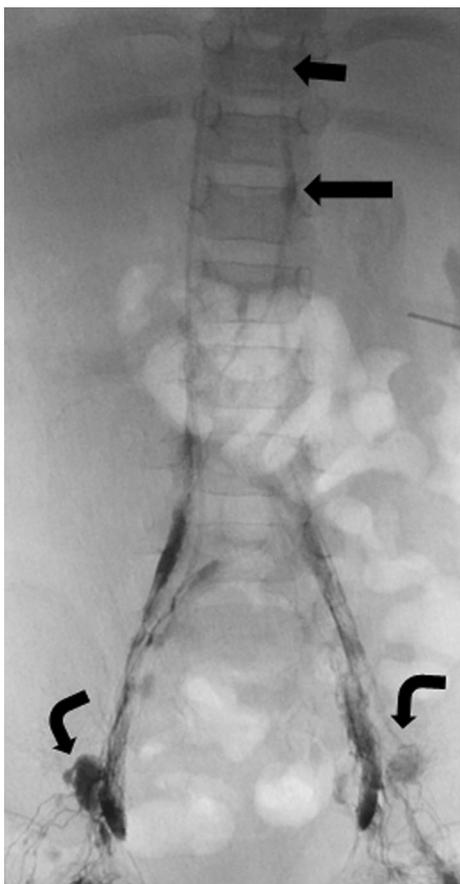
Frontal radiograph of intranodal lymphangiography using non-ionic contrast demonstrating faint opacification of the iliofemoral lymphatic vessels and nodes (bent arrows), cisterna chyli (long arrow) and thoracic duct (short arrows)
